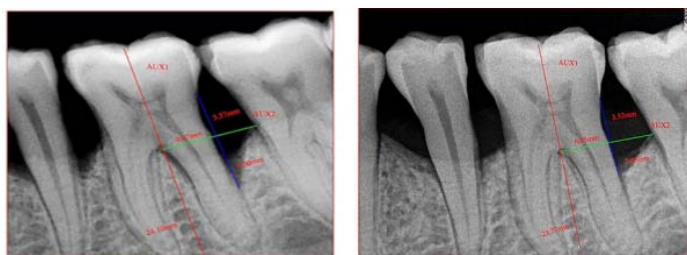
Radiographic defect depth at baseline and after 6months post treatment.
